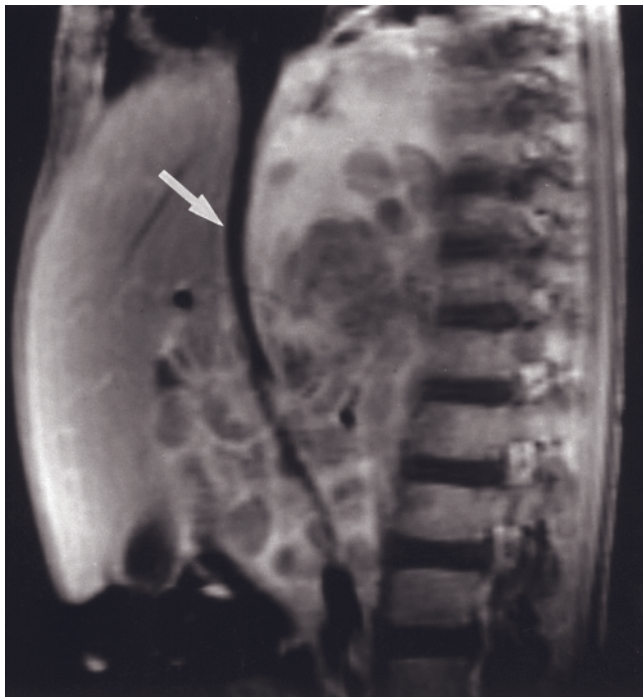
Large neuroblastoma. T1-weighted GE (a), T2-weighted echo-train spin-echo (b), immediate postgadolinium GE (c), coronal T2-weighted echo-train spin-echo (d), sagittal 10-min
